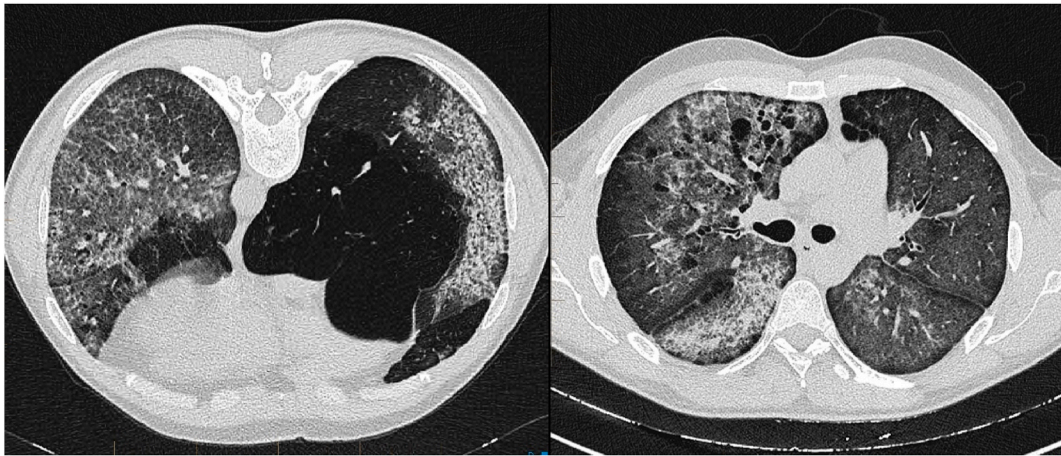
High Resolution CT Chest (at diagnosis) showing diffuse septal and reticular thickening on a background of ground glass changes consistent with ‘crazy paving’. Concurrent bullous centrilobular emphysematous changes.
